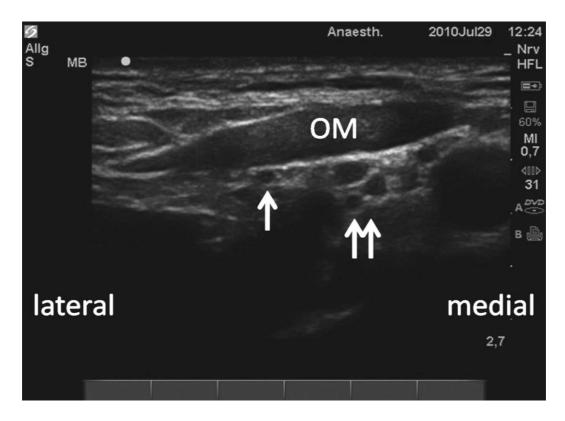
Ultrasound image of the supraclavicular region.
